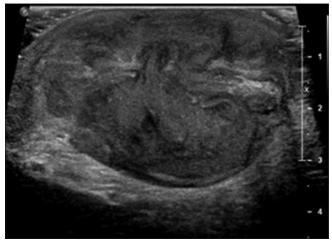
Ultrasound of the left testis in longitudinal view showing an anterior defect in tunica albuginea with extrusion of testicular contents
